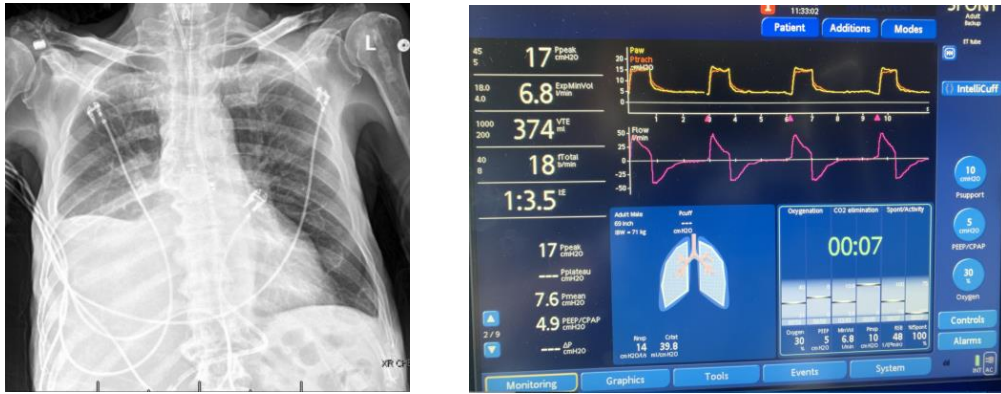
Chest x-ray taken two days after the EIT data collection. Radiology report indicates a right basilar opacity suspected to reflect a combination of pleural fluid and underlying atelectasis, but pneumonia is not excluded.
